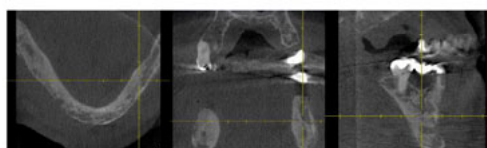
cone beam computed tomography with the primary findings 03/2012.
